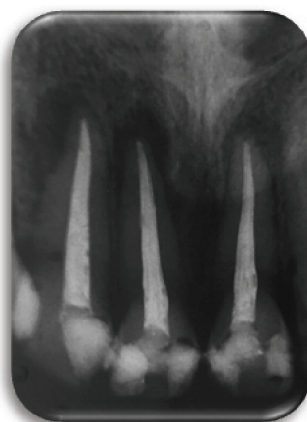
Final obturation radiograph
